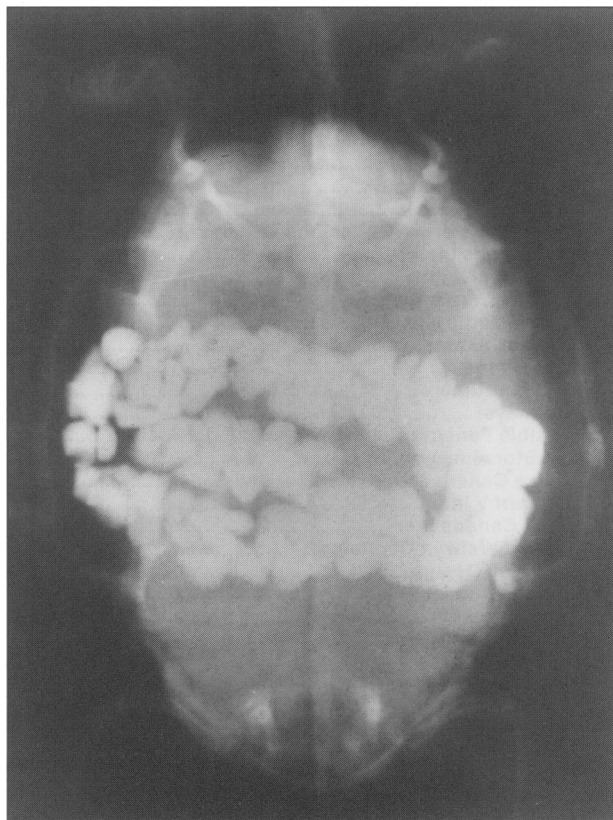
Ventrodorsal radiograph showing numerous radiopaque foreign bodies in the intestine.
